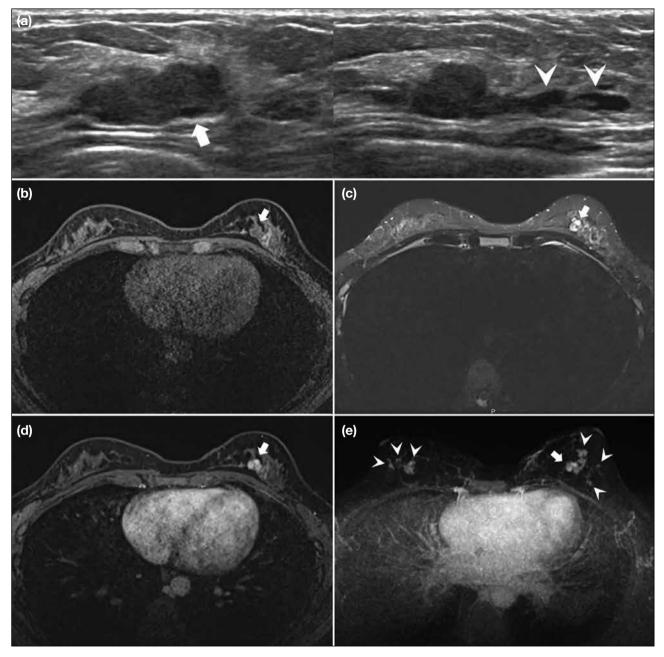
A 22-year-old female with biopsy-proven papillomatosis involving both breasts. (a) On ultrasound, the largest lesion in the left breast lower inner quadrant 2 cm from the nipple is shown to be a lobulated mass with a cystic component (arrow) and an associated dilated duct (arrowheads). Transverse plane (left) and longitudinal plane (right). (b-e) Magnetic resonance imaging shows the same lesion (arrows) to be T1-hypointense with avid contrast enhancement (d) and T2-hyperintense (c). A maximum intensity projection of the post-contrast study with subtraction (e) shows multiple avidly enhancing lesions in both breasts (arrowheads), in keeping with the diagnosis of juvenile papillomatosis.
